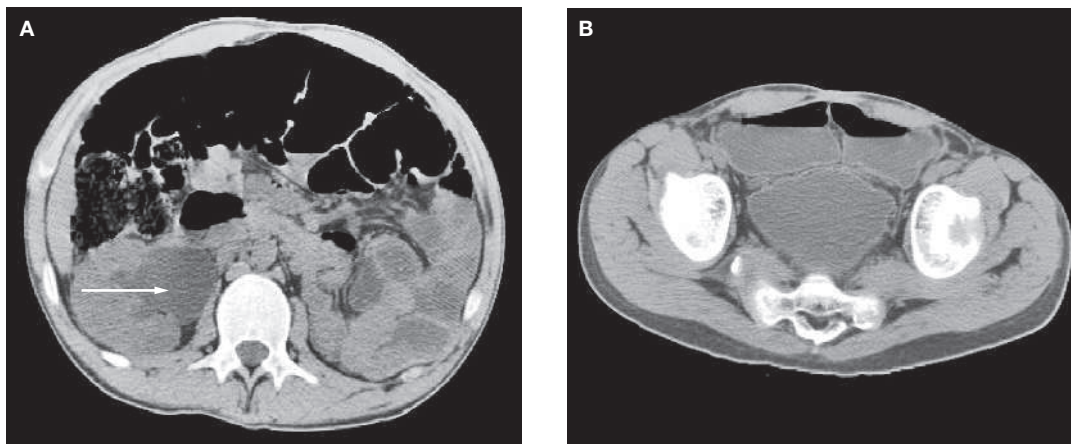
Abdominal CT scans of a patient with ureterosigmoidostomy and obstructive uropathy, showing (A) marked dilatation of the right renal pelvis (white arrow) and (B) a large amount of urine filling a wide and tortuous sigmoid colon along with part of the descending colon.
